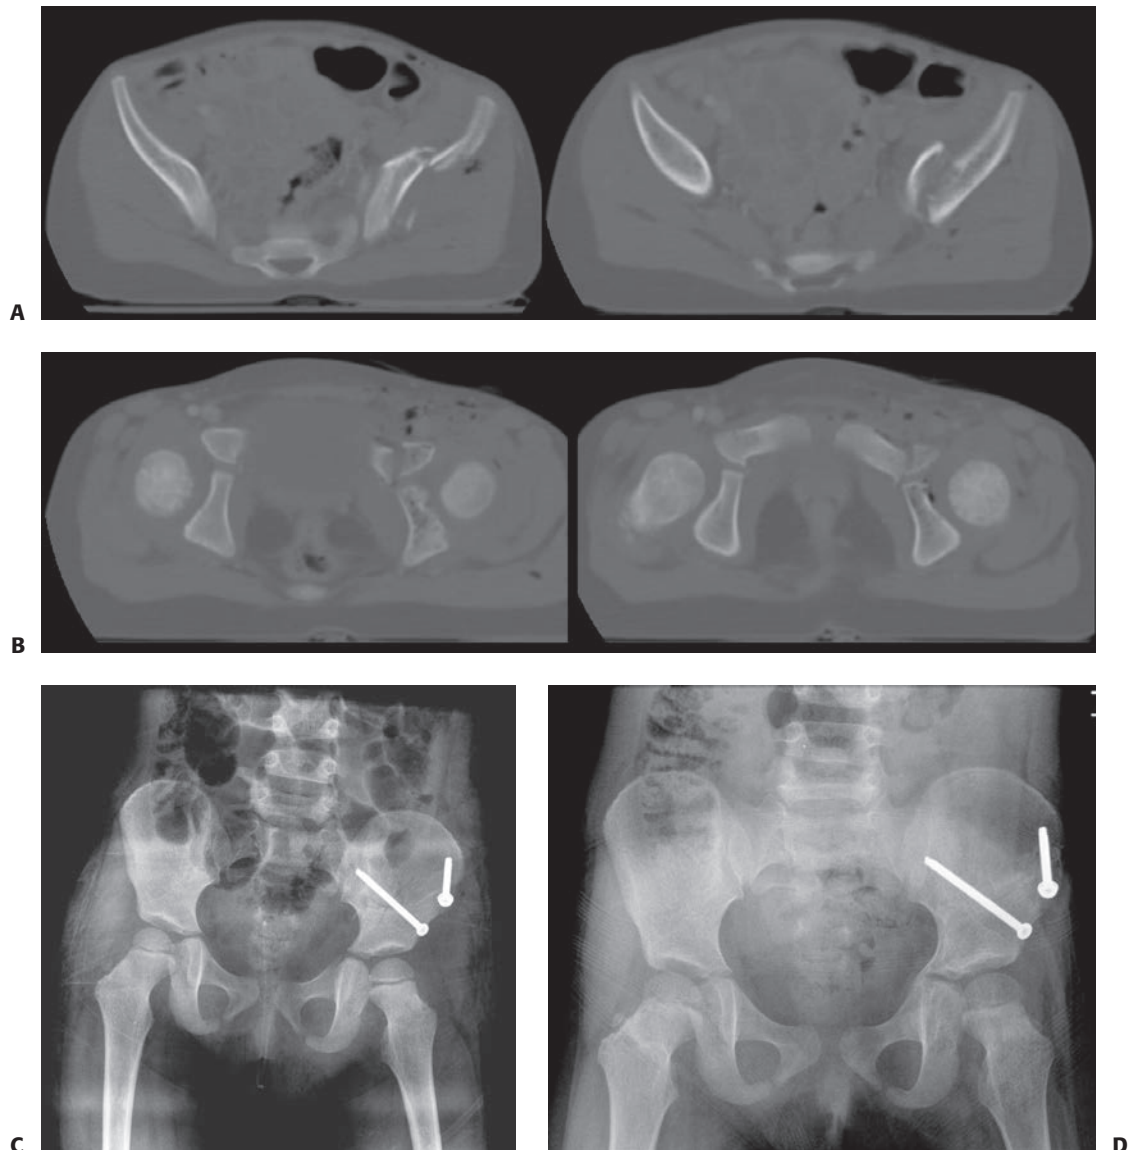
A: CT scan of a 7-year old with a displaced pelvic wing fracture B: CT scan showing the fracture propagation into the triradiate cartilage. C: Anatomic reduction of the triradiate cartilage with open reduction and internal fixation. D: Despite anatomic reduction, medial osseous bar spans the triradiate cartilage at follow-up.
